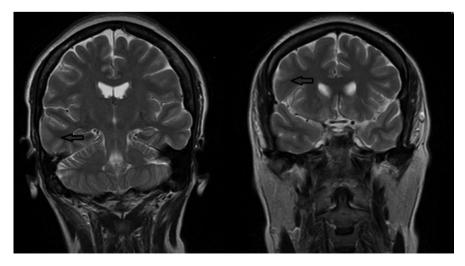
Coronal view of MRI brain showing bilateral occipital, parietal and subcortical white matter hyperintensities.
